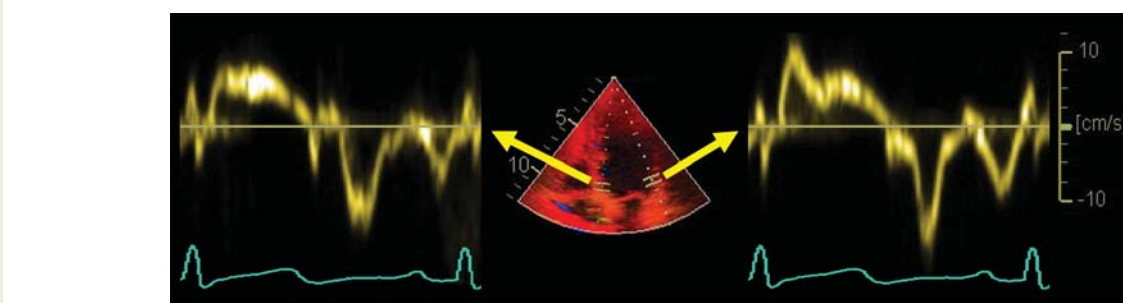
Normal tissue Doppler spectra obtained from the basal septum (left) and the basal lateral wall (right). Note the different amplitudes and shapes of the curves. Reproduced with permission from Voigt.¹⁸⁰
